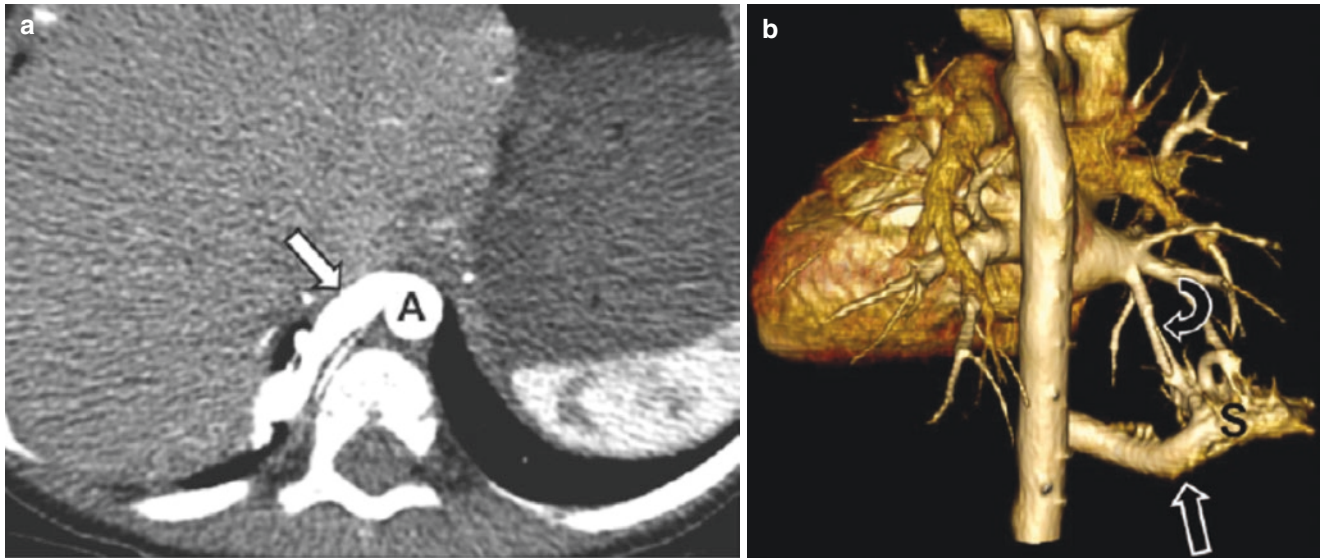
A 5-week-old girl with prenatal diagnosis of focal lung mass located in the right lower hemithorax. Surgical pathology was consistent with pulmonary sequestration. (a) Enhanced axial CT image shows an anomalous artery (*arrow*) arising from the descending aorta (letter
